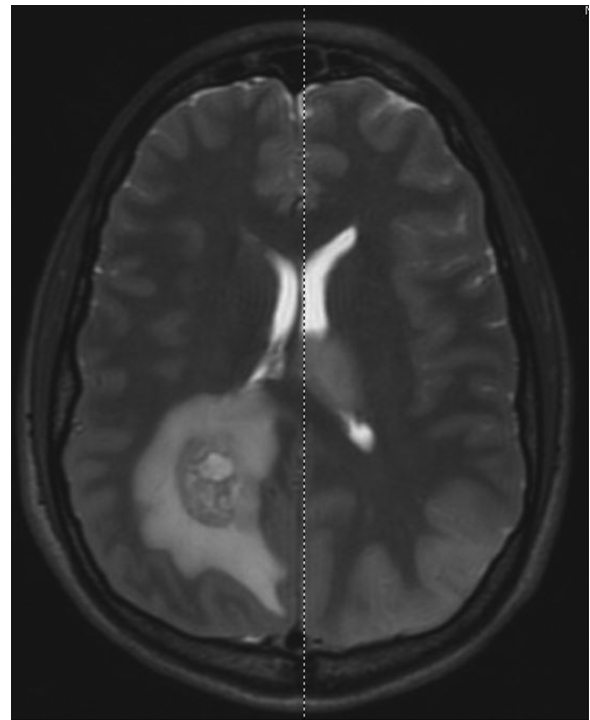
T2 MRI brain of patient 2.
